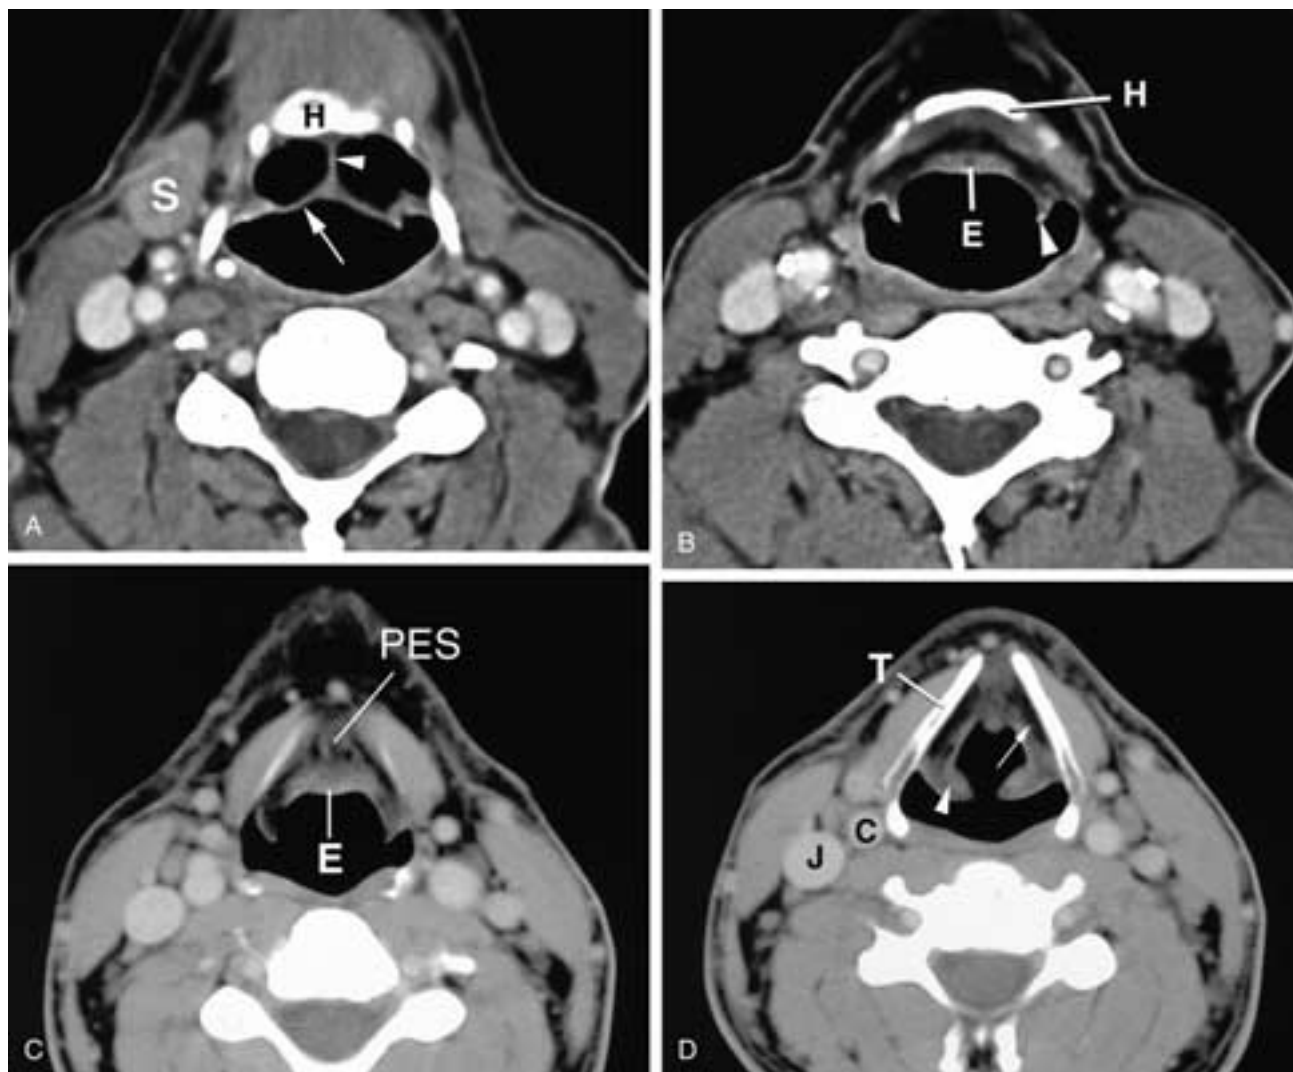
Axial CT scan through the larynx from superior to inferior. A, Hyoid (*H*) level, glossoepiglottic fold (*arrowhead*), edge of the epiglottis (*arrow*), submandibular gland (*S*). B, Hyoid (*H*), epiglottis (*E*), AE fold (*arrowhead*). C, Epiglottis (*E*), preepiglottic space (*PES*). D, Supraglottic level. Thyroid cartilage (*T*), paraglottic fat (*arrow*), AE fold (*arrowhead*), carotid artery (*C*), jugular vein (*J*).
